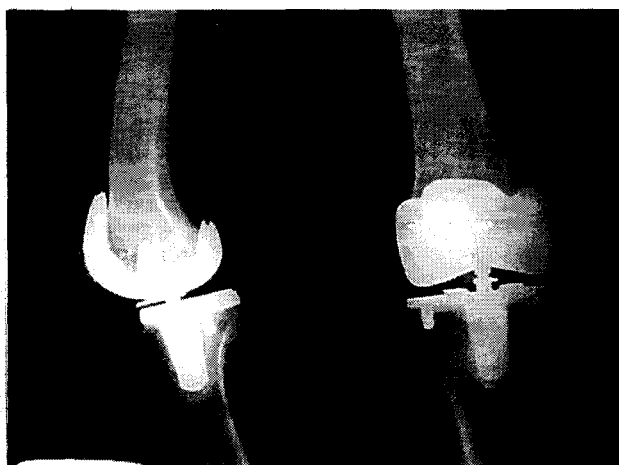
Radiographs of a typical TKR of the right limb. The polyethylene tibial insert is not shown.
